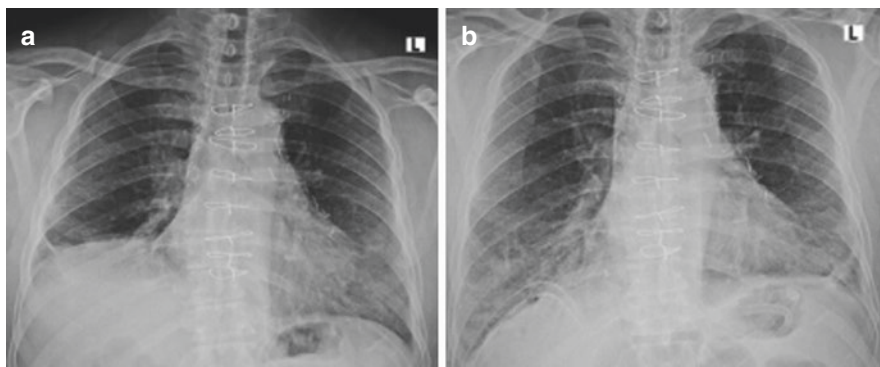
(a) Chest X-ray view of a patient with phrenic nerve paralysis. (b) Chest X-ray view of a patient after VATS diaphragmatic plication
